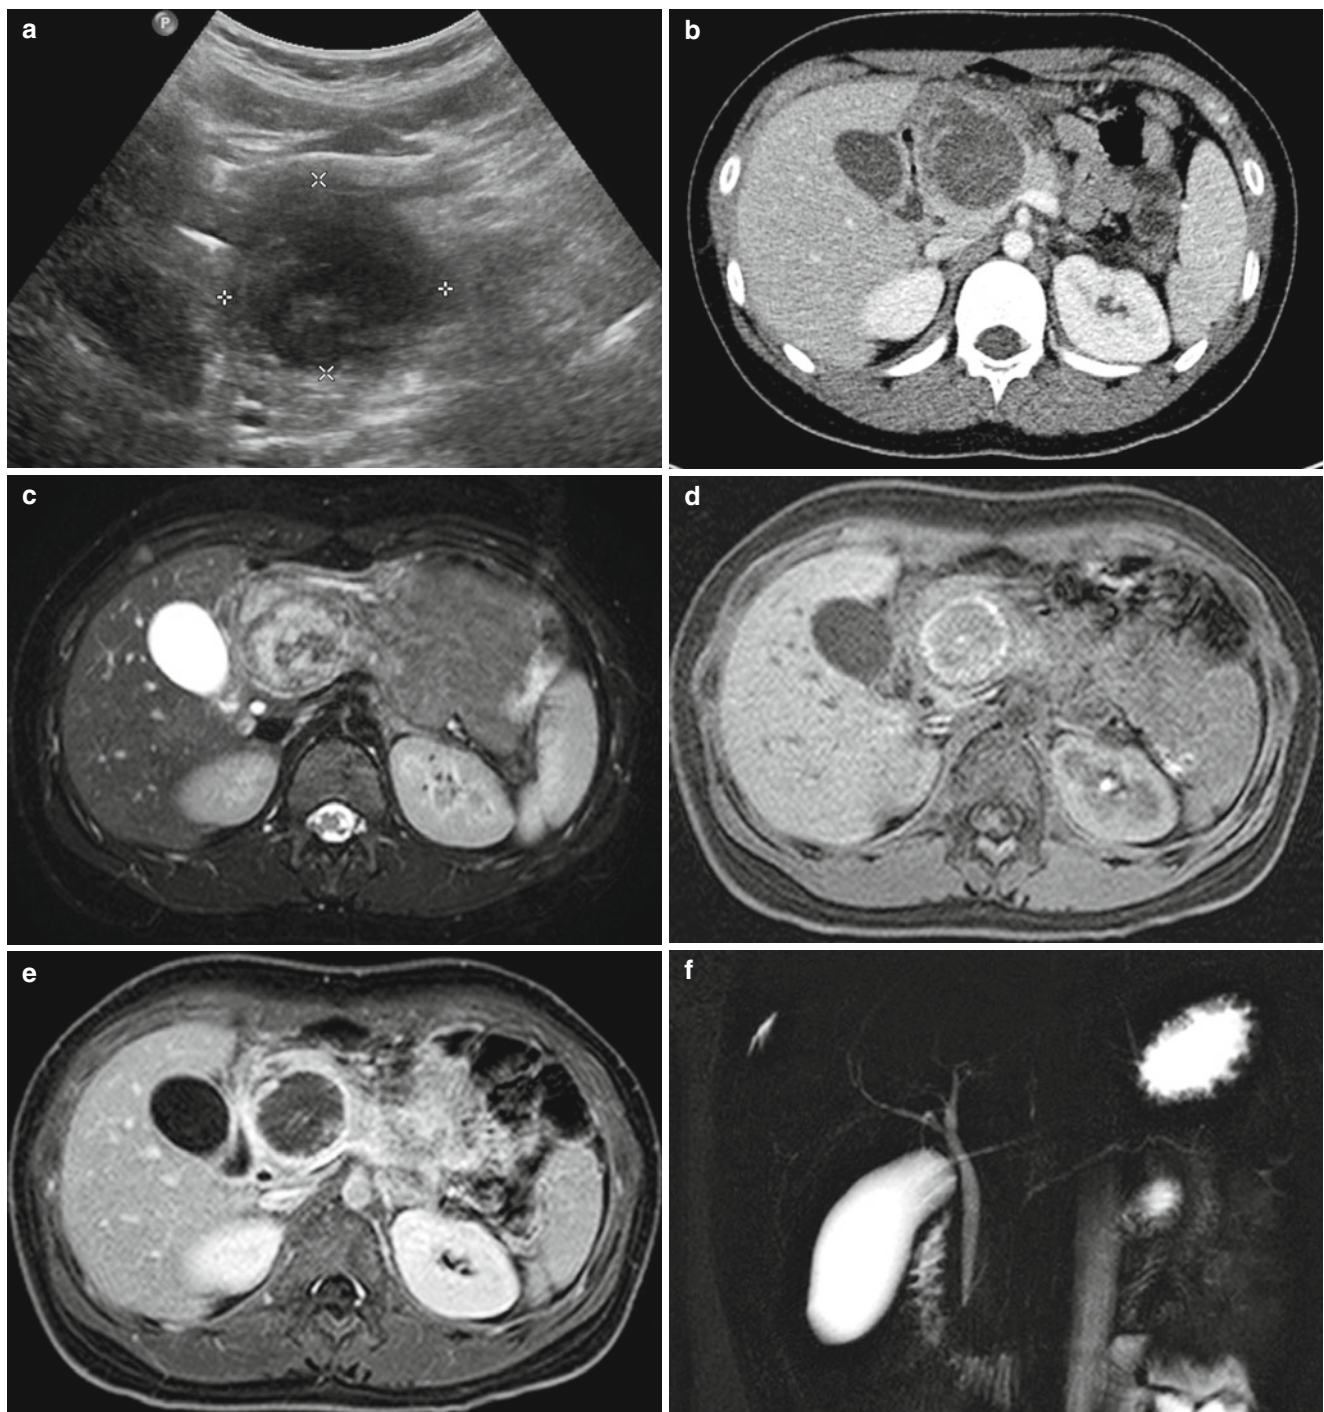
Solid and papillary epithelial neoplasm in an 11-year-old girl. (a) Abdominal US shows heterogeneously hypoechoic mass in pancreas body. (b) Contrast-enhanced abdominal CT shows lobulated low-density mass with central hyperdense portion in pancreas body. (c) On T2-weighted MR image, the pancreatic mass shows heterogeneously high-signal intensity with internal dark signal intensity portion
